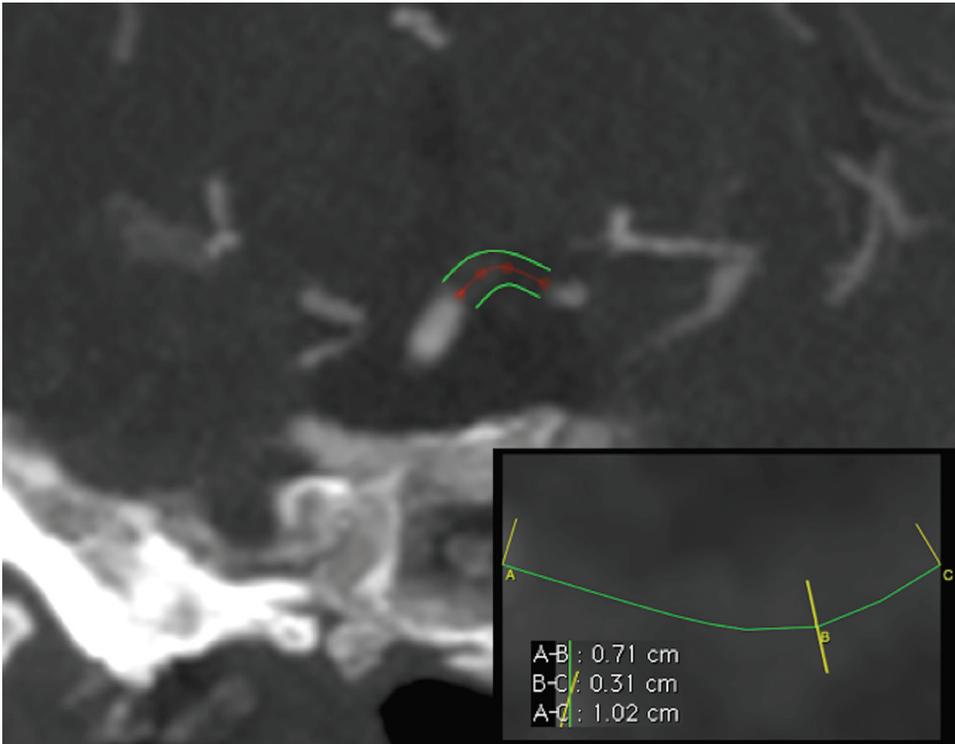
Thrombus length assessment on CTA of a patient with a top of the basilar artery occlusion with clot extending into the left posterior cerebral artery.
